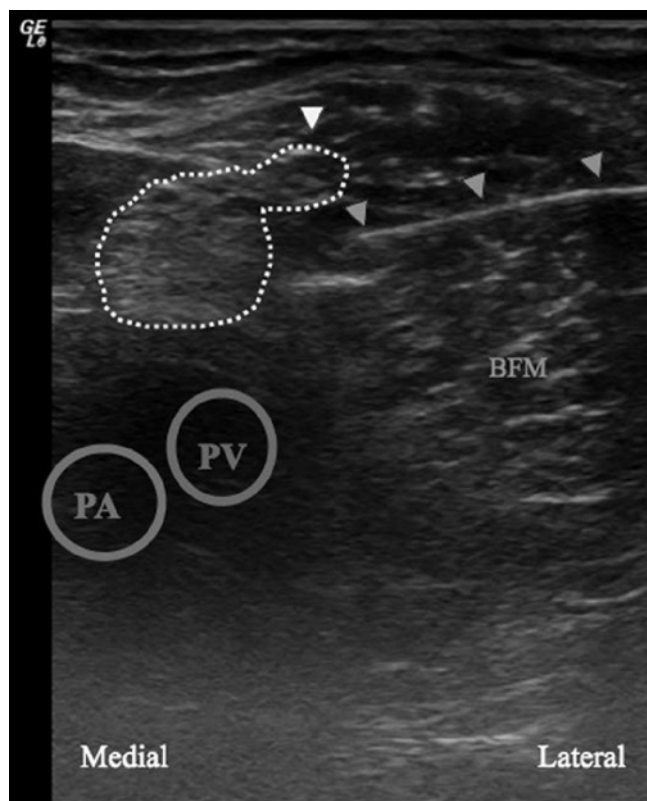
Ultrasonographic image of the sciatic nerve in the popliteal fossa.
